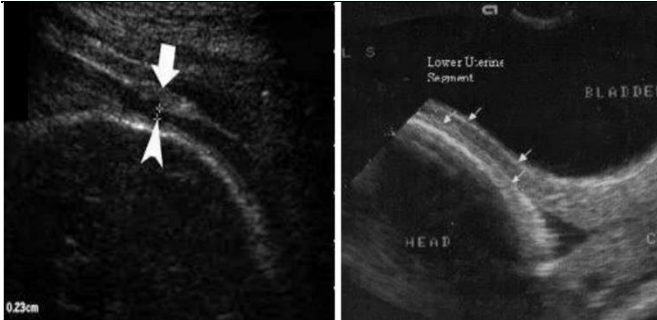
Ultrasound measurement of uterine scar thickness.
